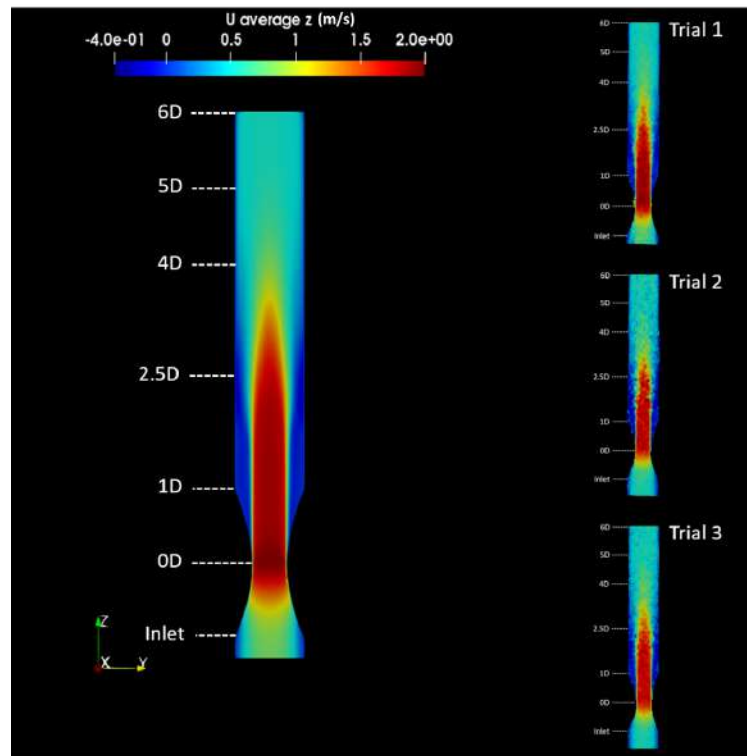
Sagittal slice of the LES and 2D PC-MRI stenosis model (y-z view) showing flow separation at  $Re\ 2000$ .
